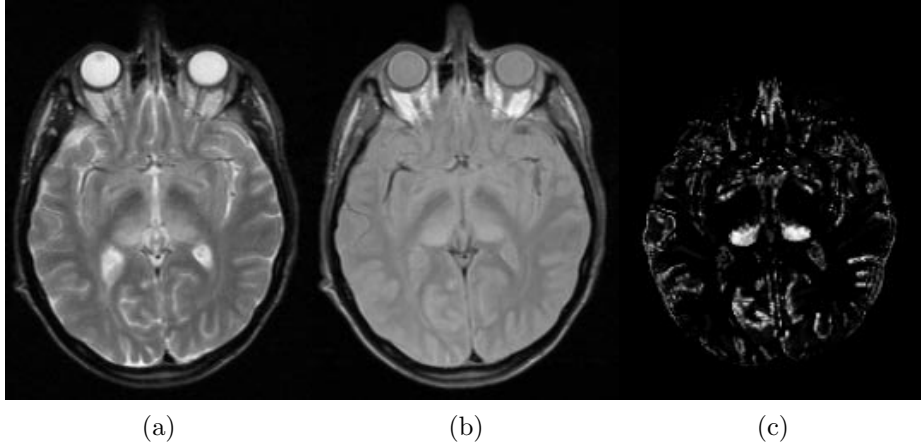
Outlier detection on a brain MR scan of a patient suffering from variant CJD. T2-weighted image (a); PD-weighted image (b); outlier belief values (c).
